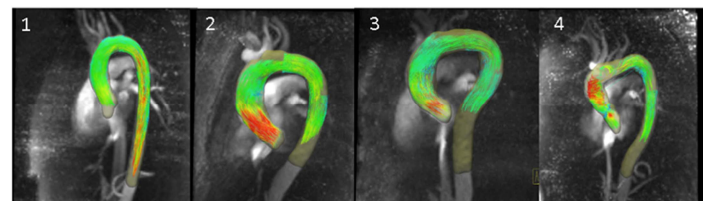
3D streamlines for blood flow visualization at 4D flow MRI in representative datasets from (1) a healthy control, and patients with (2) thoracic aortic aneurysm, (3) aortic valve stenosis and (4) aortic valve insufficiency.
